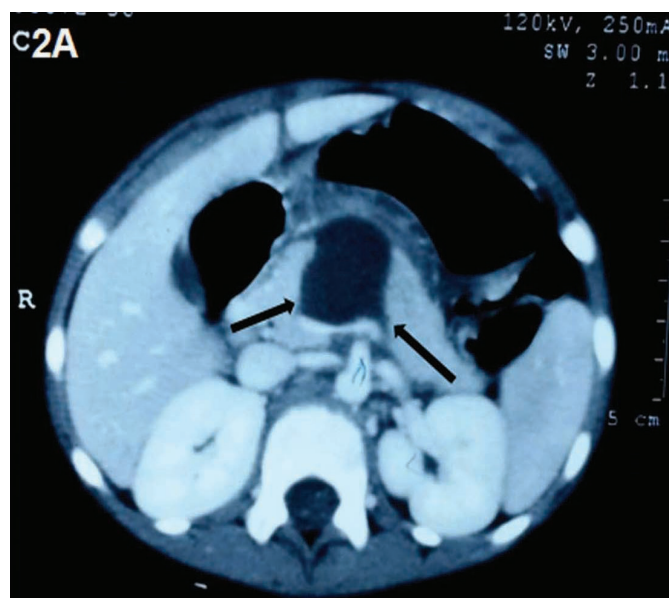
CT scan showing a large hematoma (arrow) in the neck and body area of pancreas.
